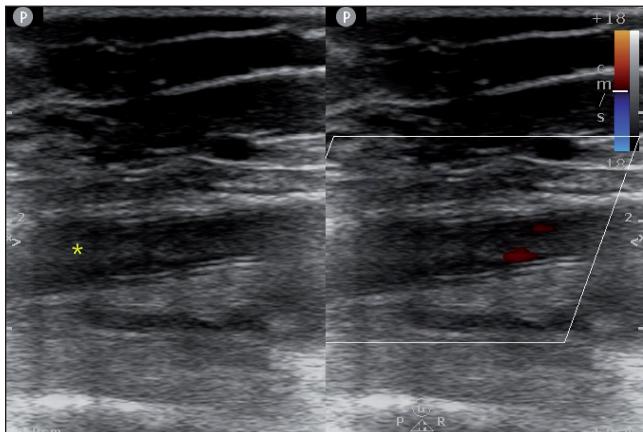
Doppler ultrasound of the right common femoral artery showed thrombus (asterisk) without flow.
